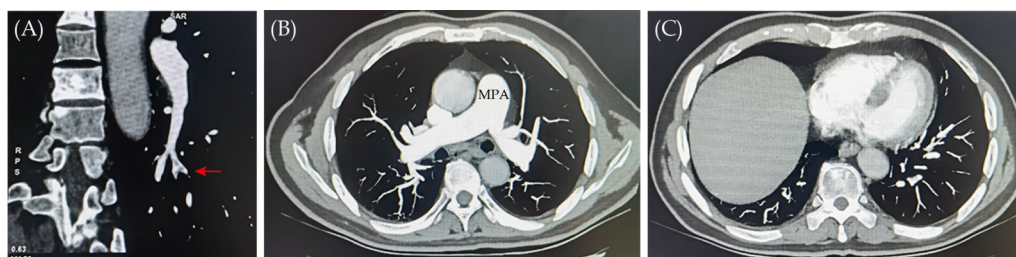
Computed tomography pulmonary arteriography showing a 12 mm hypodense filling defect in the artery of the posterior basal segment of the left lower lung (A) (red arrow) and signs of pulmonary hypertension: dilated main pulmonary artery of 32 mm (B), mildly dilated right atrium and mildly dilated right ventricle with flattening of the interventricular septum (C).
